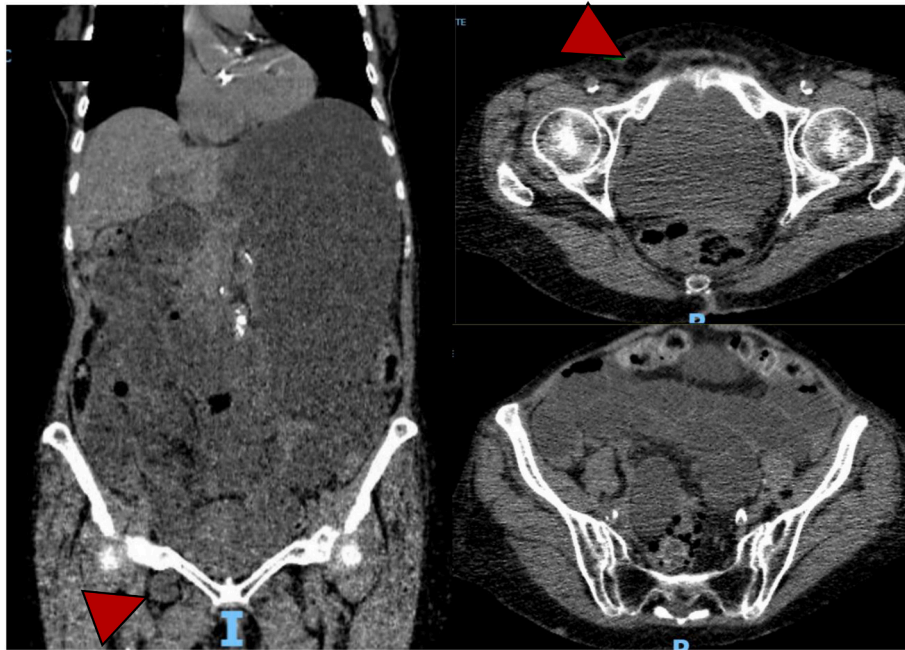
No contrast CT scan reveals an obturator hernia (indicated by the arrowhead) accompanied by dilated small bowel loops and gastric cavity.
